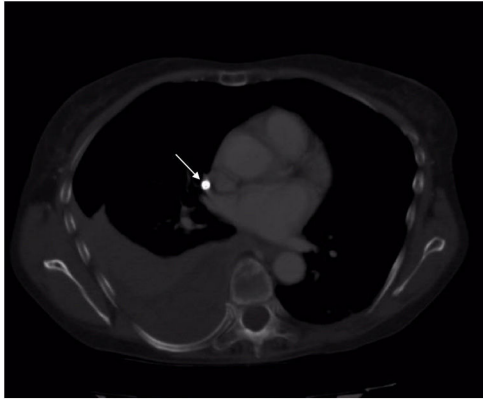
Thoracic CT angiogram with extravasation of the central venous catheter (arrow) and associated hemothorax.
